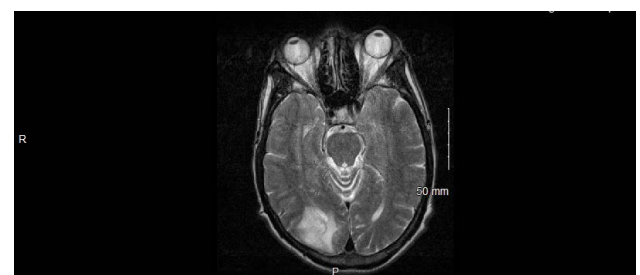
Brain MRI showed right occipital intracranial metastasis with adjacent vasogenic edema.
